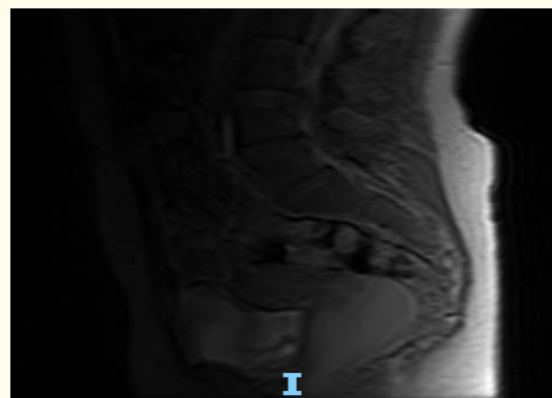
MRI showing (vaginal collection), normal size uterus.
